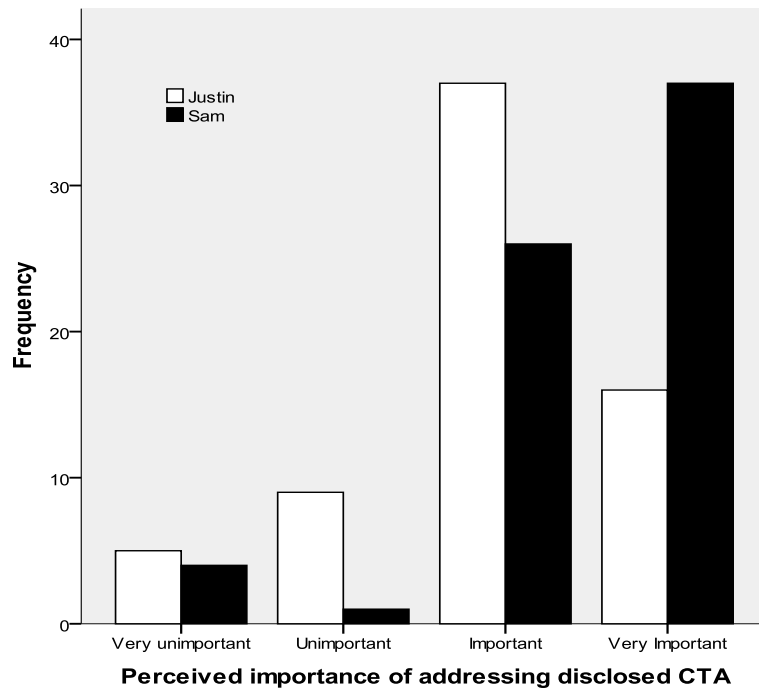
Perceived importance of addressing disclosed CTA across both vignettes.
